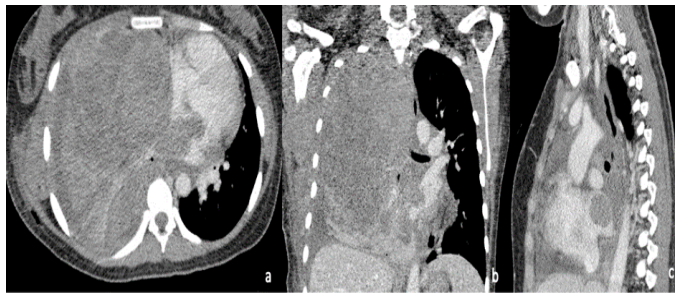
above shows axial (a), coronal (b), sagittal (c) of contrast-enhanced CT thorax. These images showed lobulated heterogeneous hypodensity occupying the entrance of the right superior pulmonary vein, extending to the left atrium.
